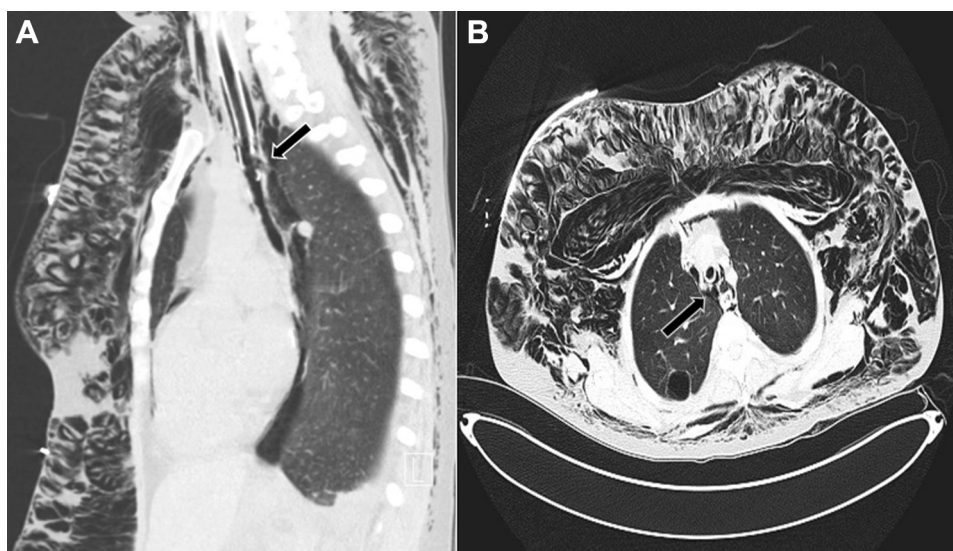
A and B, Example of endotracheal intubation-related airway injury with full-thickness posterior membranous tear (arrow) complicated by pneumomediastinum on a sagittal reformatted CT image (A), and subcutaneous emphysema on an axial CT image (B).
